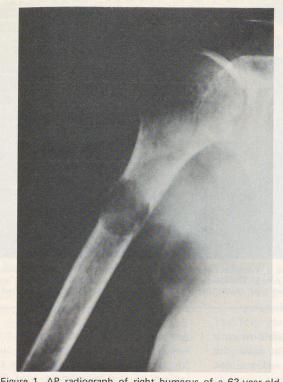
AP radiograph of right humerus of a 63-year-old female suffering from breast carcinoma. There is a large lytic lesion involving the upper quarter of the humerus. This is an impending pathological fracture.
